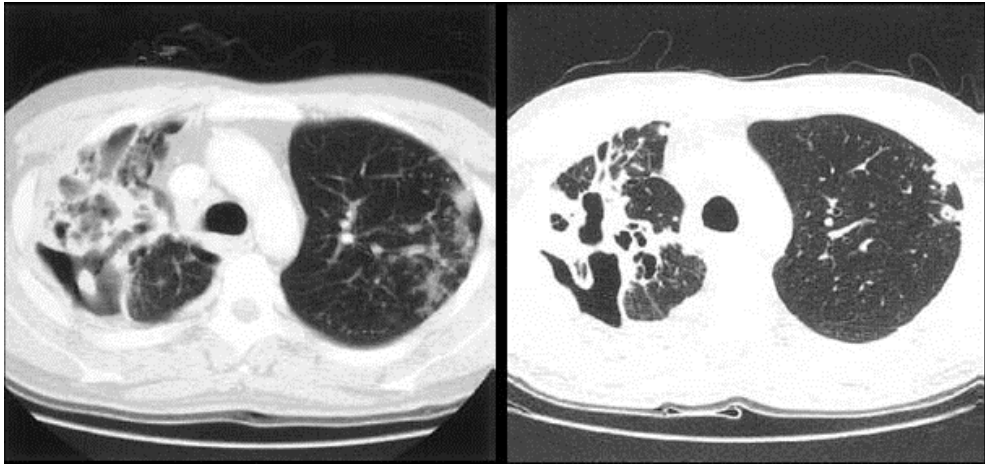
27-yr-old male patient with MDR-TB. (Left image) Computed tomographic scan of the chest showed multiple cavities in the right upper lobe and big nodular infiltrations in the left upper lobe. (Right image) After 6 months of IFN gamma inhalation therapy, computed tomographic scan showed reduction in the size of cavitary lesions and improvement of nodular infiltrates. (Picture taken from Koh et al., 2004).
